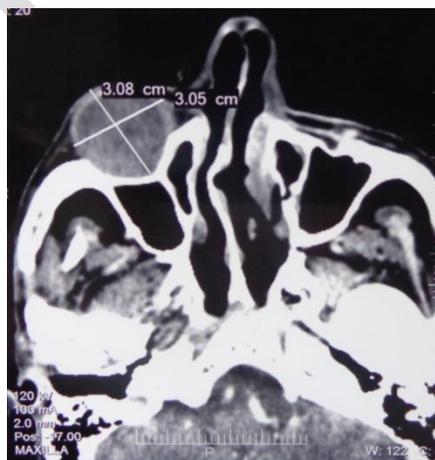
Showing extent of lesion in axial CT Scan
